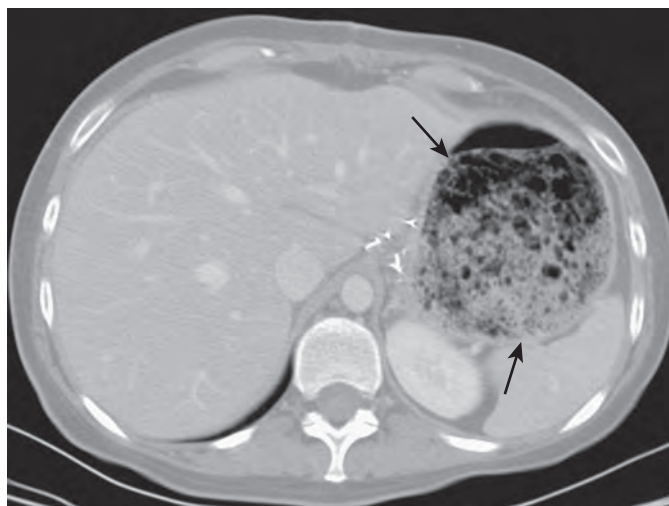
Gastric bezoar on CT. The bezoar is characterized on CT by an inhomogeneous intraluminal mass with a mottled gas pattern (arrows). This patient underwent a partial gastrectomy and now has a bezoar in the gastric remnant because of a stricture at the gastrojejunal anastomosis (not visualized on this image). (From Woodfield CA, Levine MS: *The postoperative stomach*. *Eur J Radiol* 53:341–352, 2005.)
